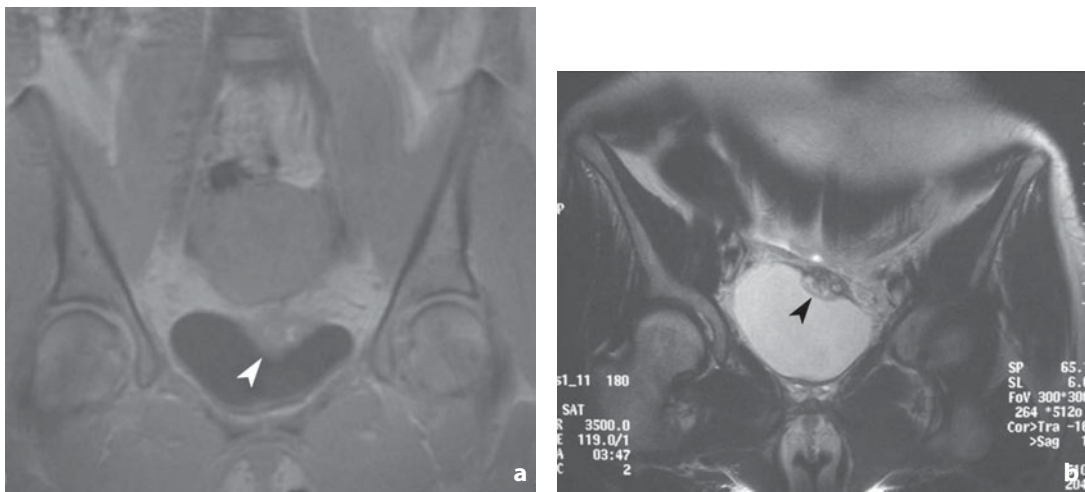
Magnetic resonance. Bladder endometriosis. Solid nodule in the superior bladder wall modifying the appearance of the mucosal surface. The nodular lesion (*arrowhead*) appears isointense to the muscular wall in the T1-weighted sequence (a) with hyperintense internal microfoci, and hyperintense in the T2-weighted sequence (b)
